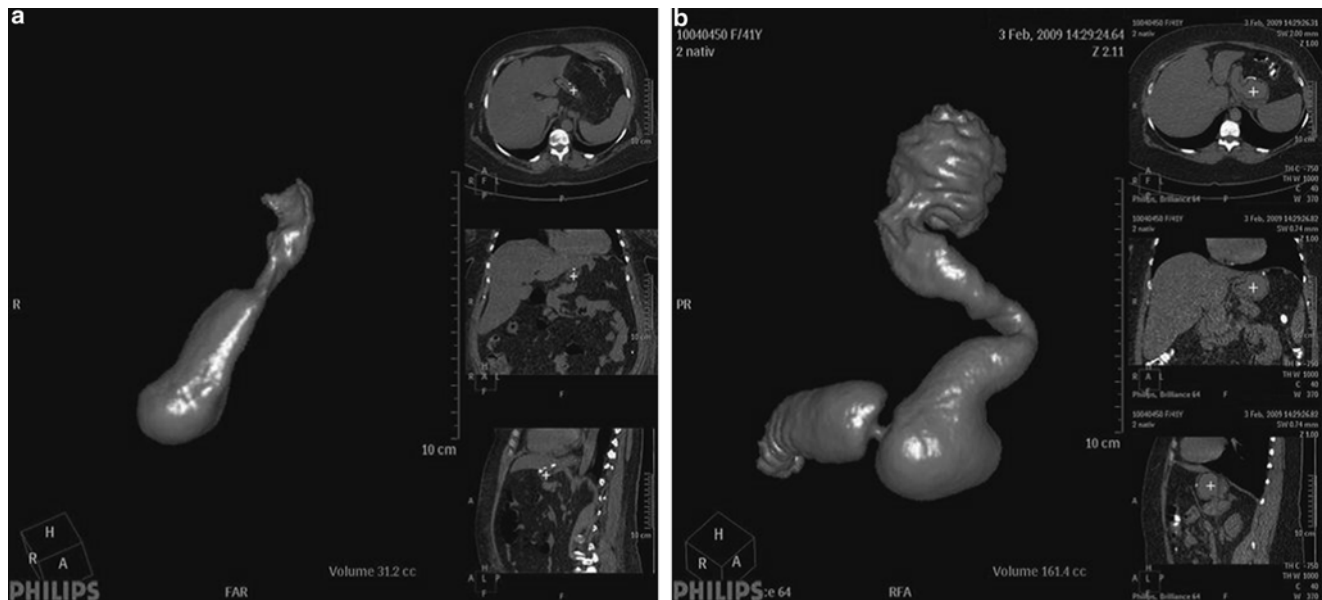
(a) Virtual CT after sleeve gastrectomy third postoperative day: normal finding after calibration with 42-Fr tube. (b) Virtual CT after sleeve gastrectomy: surgical mistake with fundus in place (uncompleted resection).
